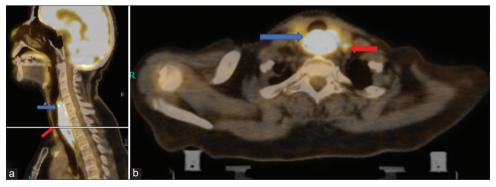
(a) Pre-chemo radiation PET/CT sagittal view showing hypermetabolic circumferential soft tissue thickening, involving the cervical esophagus from C5 to T1 level measuring 30 x 21 x 65mm with volumetric SUVmax of 15.8 (blue arrow) along with FDG avid left supraclavicular lymph node, measuring 9.5 x 9.7 mm with SUVmax of 3.7 (red arrow). (b) Pre-chemoradiation PET/CT axial view showing hypermetabolic circumferential soft tissue thickening, involving the cervical esophagus from C5 to T1 level measuring 30 x 21 x 65mm with volumetric SUVmax of 15.8 (blue arrow) along with FDG avid left supraclavicular lymph node, measuring 9.5 x 9.7 mm with SUVmax of 3.7 (red arrow)
